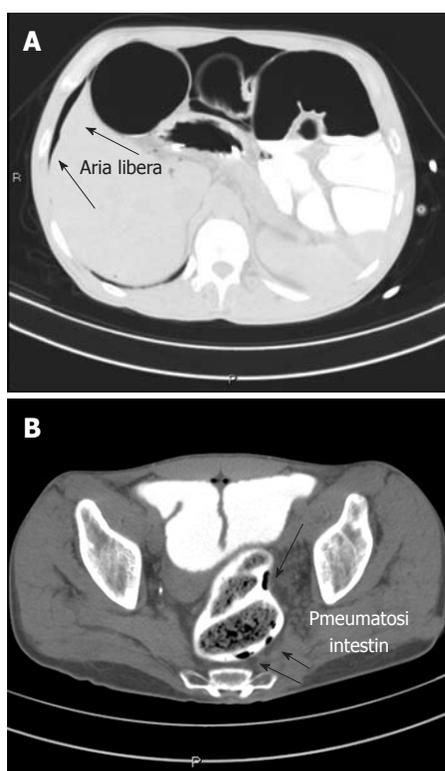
Computed tomography scan image. A: Presence of free air (arrows) in the abdomen; B: Presence of air in the bowel wall (arrows).
